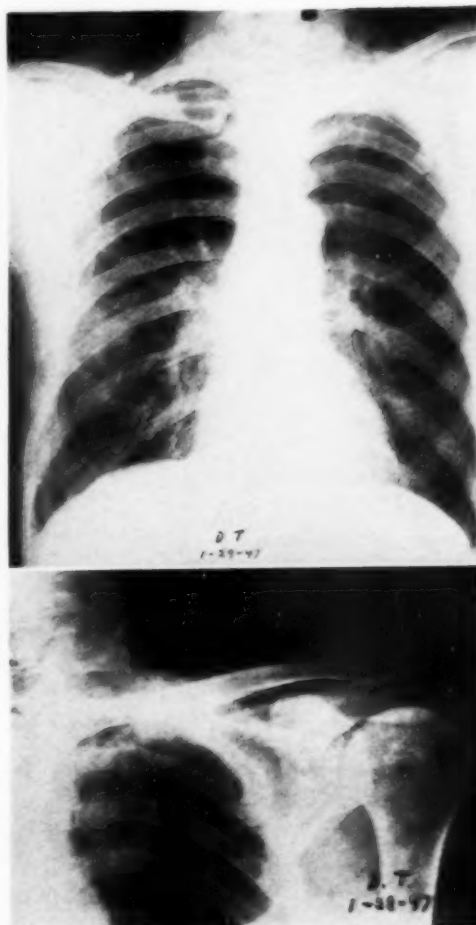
Case 4. Roentgenograms showing obscuration of the left apex, erosion of the first rib, and a soft-tissue mass not sharply defined.
